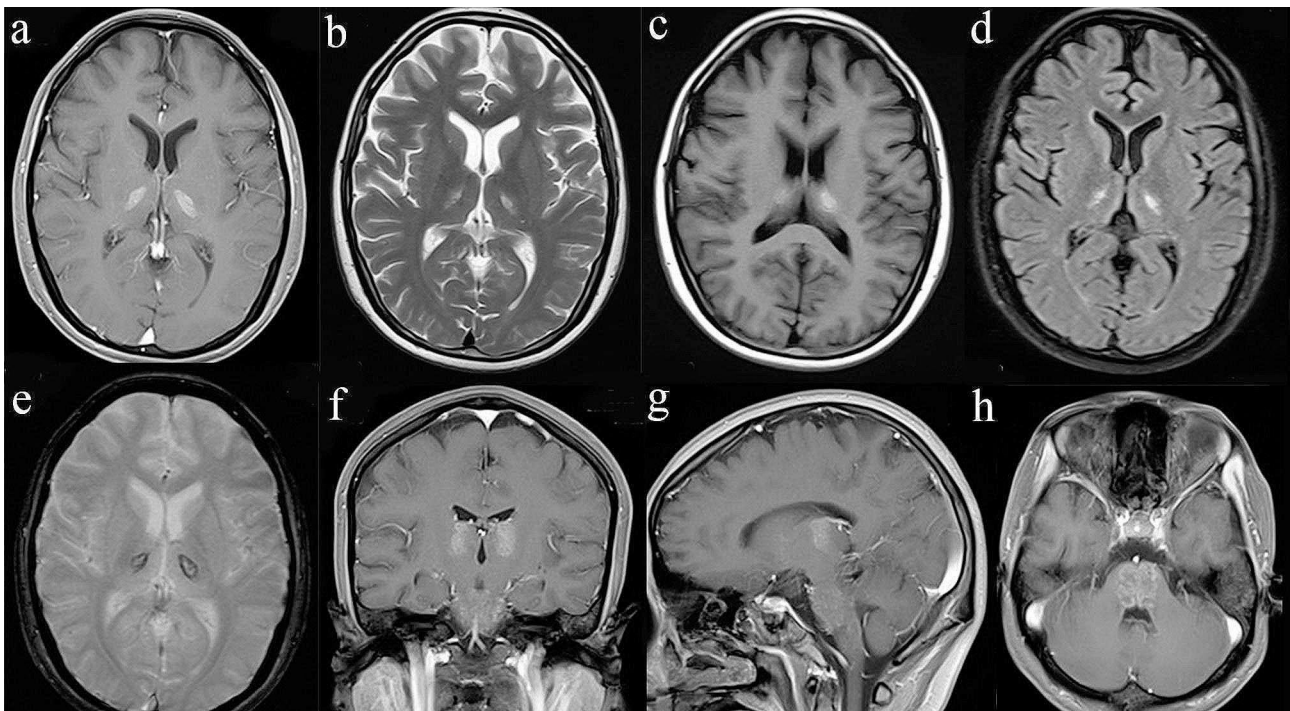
MRI findings in the patient with acute necrotizing encephalopathy. Patchy and uneven elongated T1 and T2 signals were observed in the pons and bilateral hippocampal regions, with unclear borders, punctate and patchy enhancements. Patchy short T1 and slightly long T2 signals were seen in the basal ganglia regions on both sides, with low signal rims at the edges
